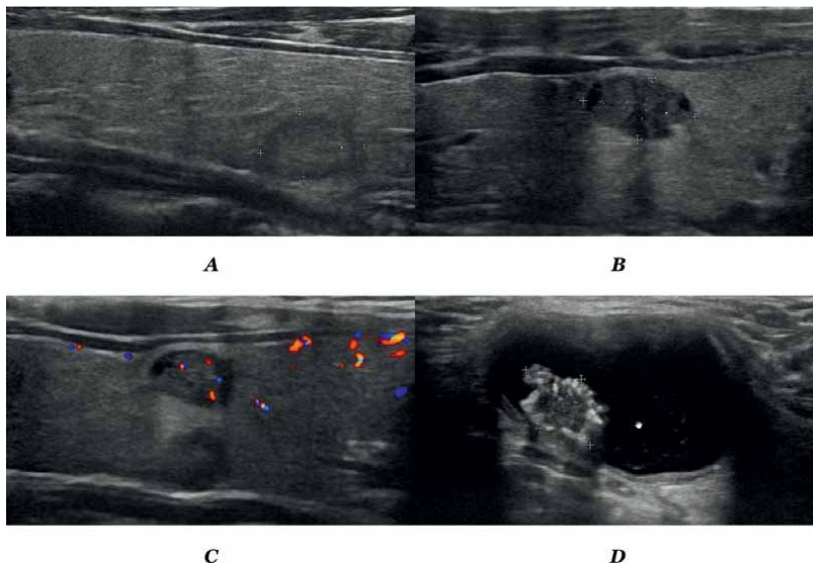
Multiple thyroid nodules with co-existence of benign and malignant ultrasonic features. (A) shows that a nearly isoechoic nodule was at the middle-to-lower portion of left thyroid lobe in a 41-year-old male patient, rating the score of TI-RADS 4a. FNAC confirmed it as benign thyroid nodule. (B) shows that a hypoechoic nodule was at the middle portion of right thyroid lobe in the same patient, rating the score of TI-RADS 4b. FNAC confirmed it as PTC. (C) shows that two hypoechoic nodules were at the middle portion of left thyroid lobe in the same patient, rating the score of TI-RADS 4a to 4b. FNAC finally confirmed them all as PTC. (D) shows that a cystic-dominant solid nodule was at the isthmus of thyroid with a papillary and calcified solid clump at the bottom of the cyst in the same patient, rating the score of TI-RADS 4b. FNAC finally confirmed the solid nodule as PTC.
